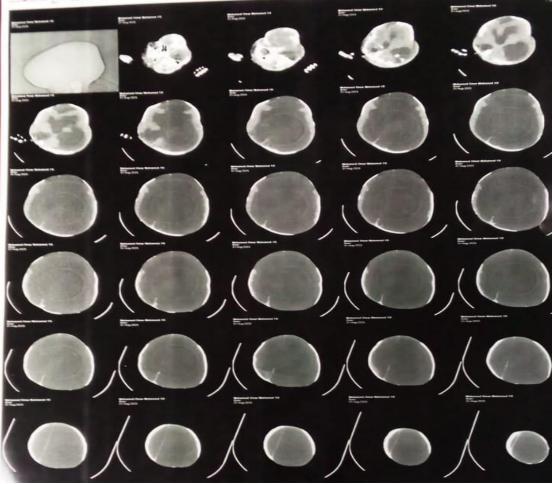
CT of the newborn (of Fig,11) showing supratentorial hydrocephalus.
